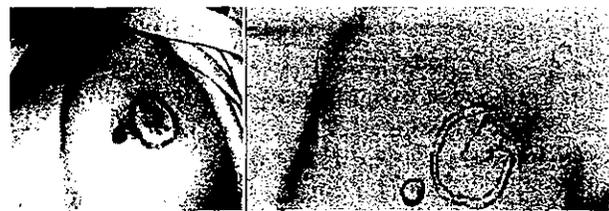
The skin marking for resection made by a surgeon was misaligned, and the marking was adjusted to the correct position according to the 3D helical CT image.
